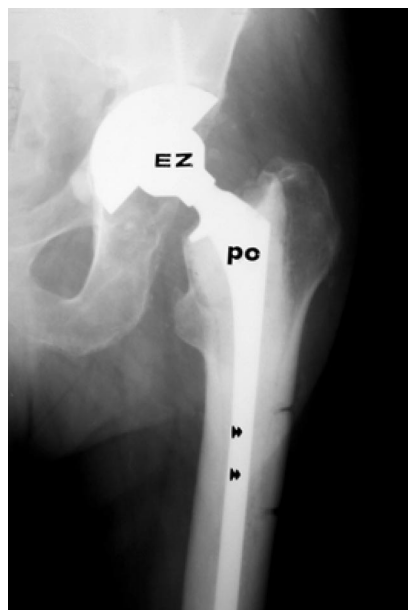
Radiograph taken shortly after replacement of a bony window that had been surgically created to facilitate the removal of a failed arthroplasty. The bony window was pressed over the still doughy acrylic cement (a), and radiograph obtained nine months later showing incorporation of the window into the femoral cortex (b).
